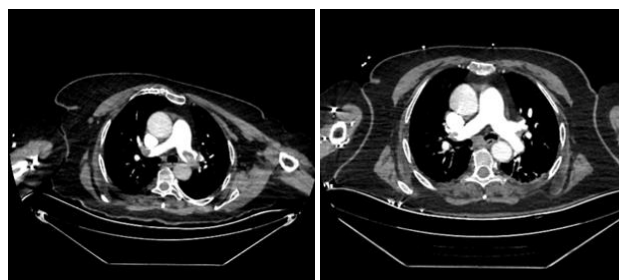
Computed tomography pulmonary angiography images of Case 3 before (A) and 48 hours after ultrasound-facilitated catheter-directed thrombolysis (B).
